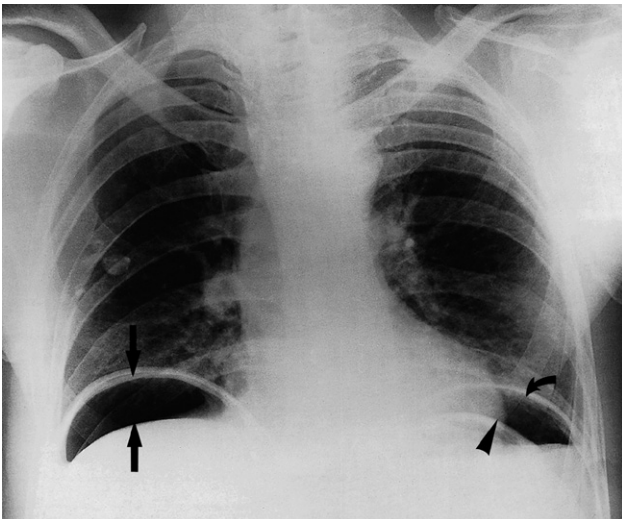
Free gas in the peritoneal cavity. On this chest radiograph, air can be seen under the domes of both hemidiaphragms. The curved arrow points to the left hemidiaphragm and the arrow head to the wall of the stomach. The two vertical arrows point to the diaphragm and upper border of the liver.
